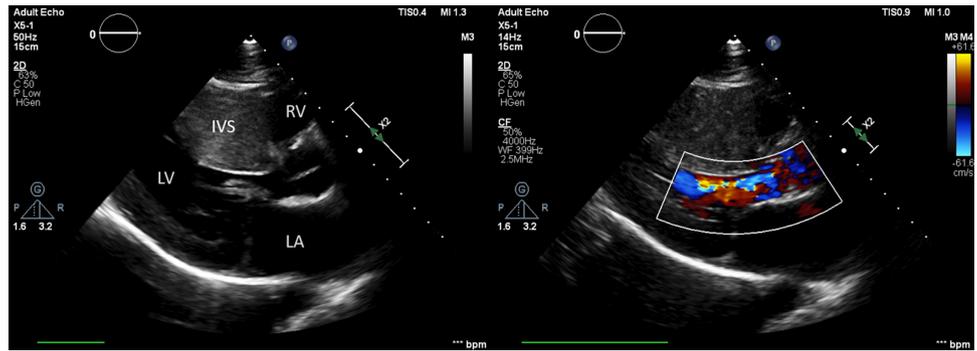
Transthoracic echocardiogram showing systolic anterior motion of mitral valve and left ventricular outflow tract obstruction (peak gradient across outflow tract was 52 mmHg).
